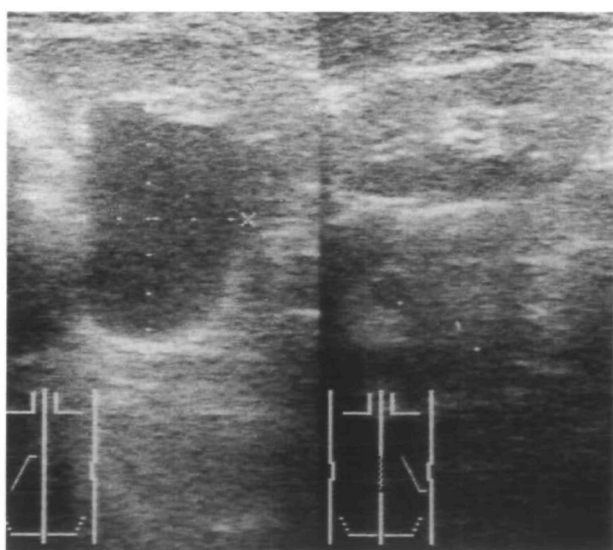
Ultrasound examination of the left kidney showed 6.6 × 4.0 cm echo free lesion on the left renal pelvis.
